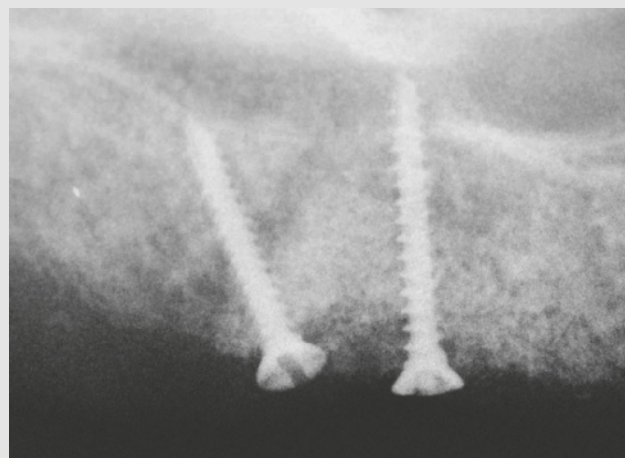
Intraoral radiographic control at 5 months.
